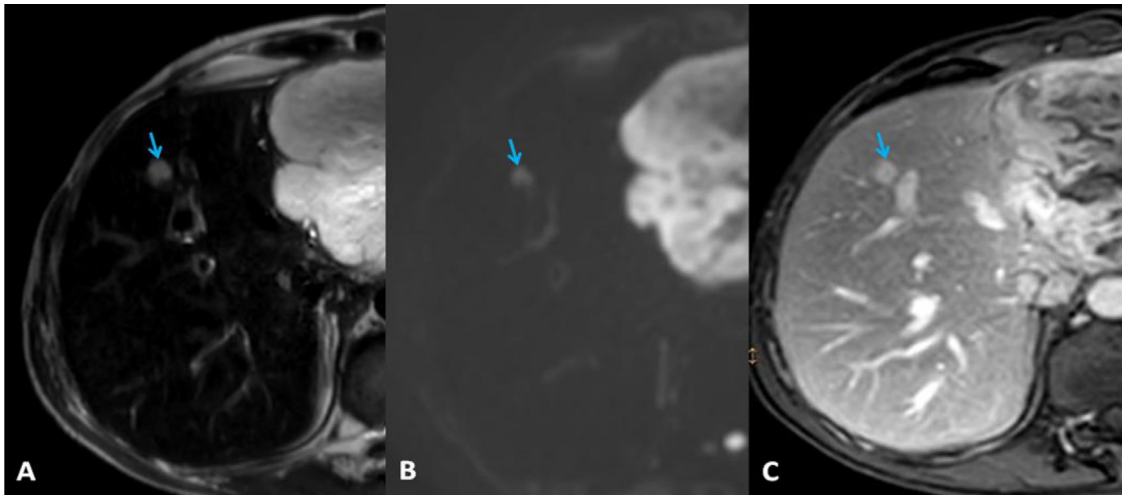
MRI findings showing an intrahepatic metastasis (blue arrows) hyperintense on T2 weighted images (A), DWI (B) and enhanced on contrast enhanced imaging (C).
